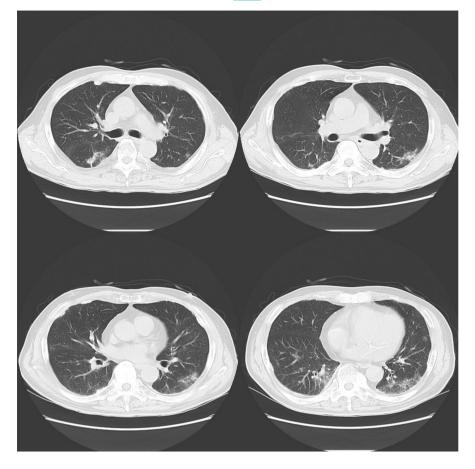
Lung computed tomography images acquired at admission.
